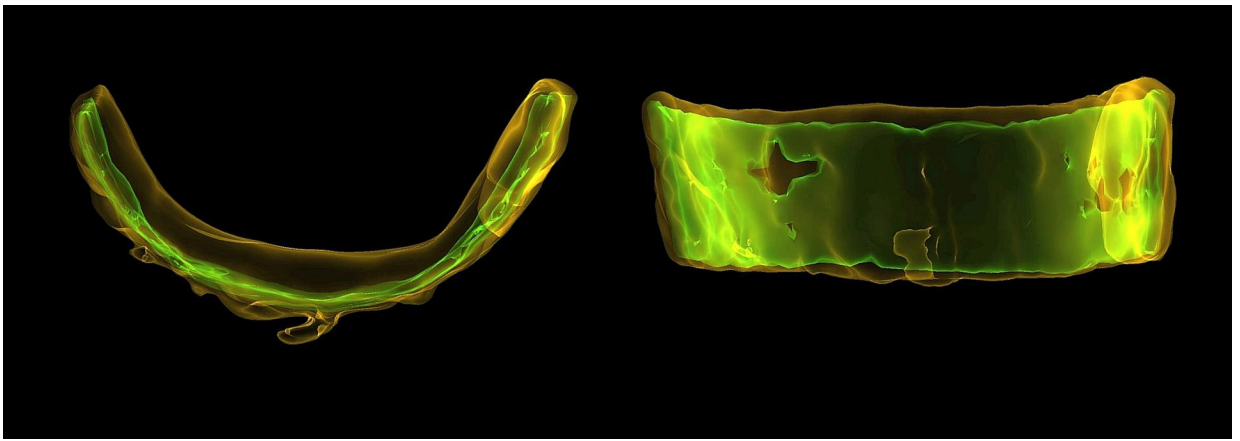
3D CT of metallic neck implant in semi-transparency showing eccentric inner core with higher CT value (*in green colour*).
